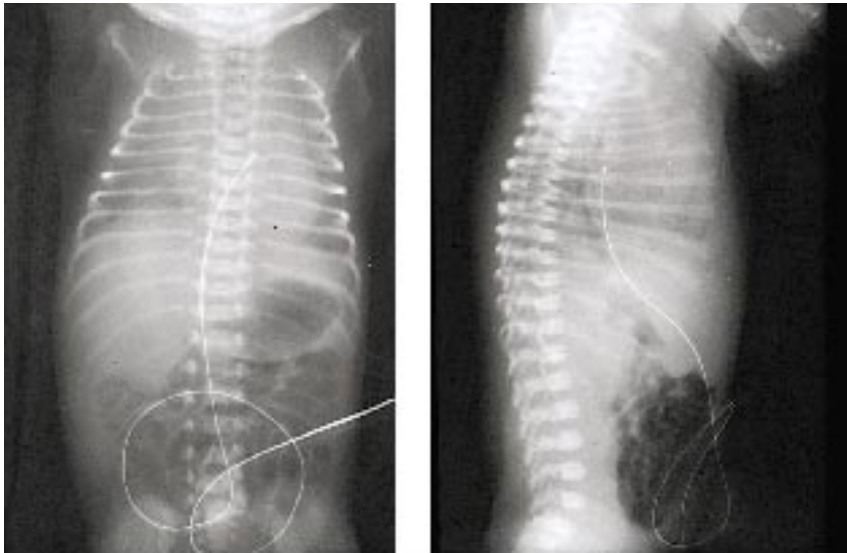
Anteroposterior and lateral radiographic views of an umbilical venous catheter placed high in the heart. It is possible to sample oxygenated left atrial blood when the catheter passes across the patent foramen ovale.
